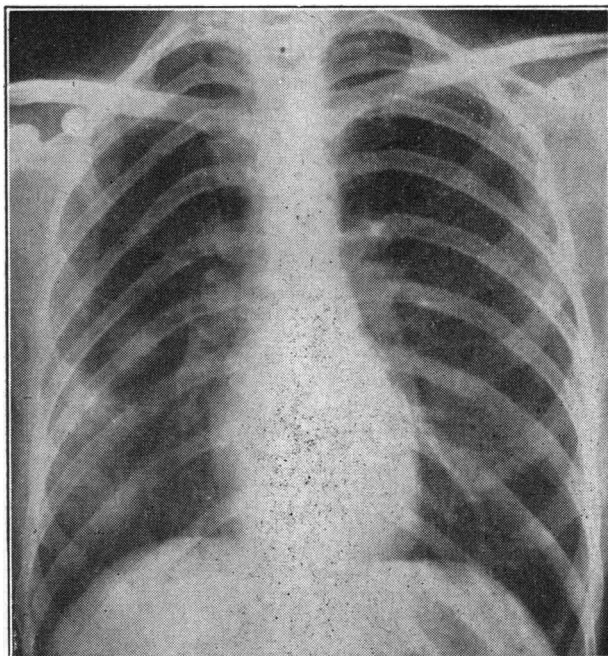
Chest x-ray film before beginning of treatment.
